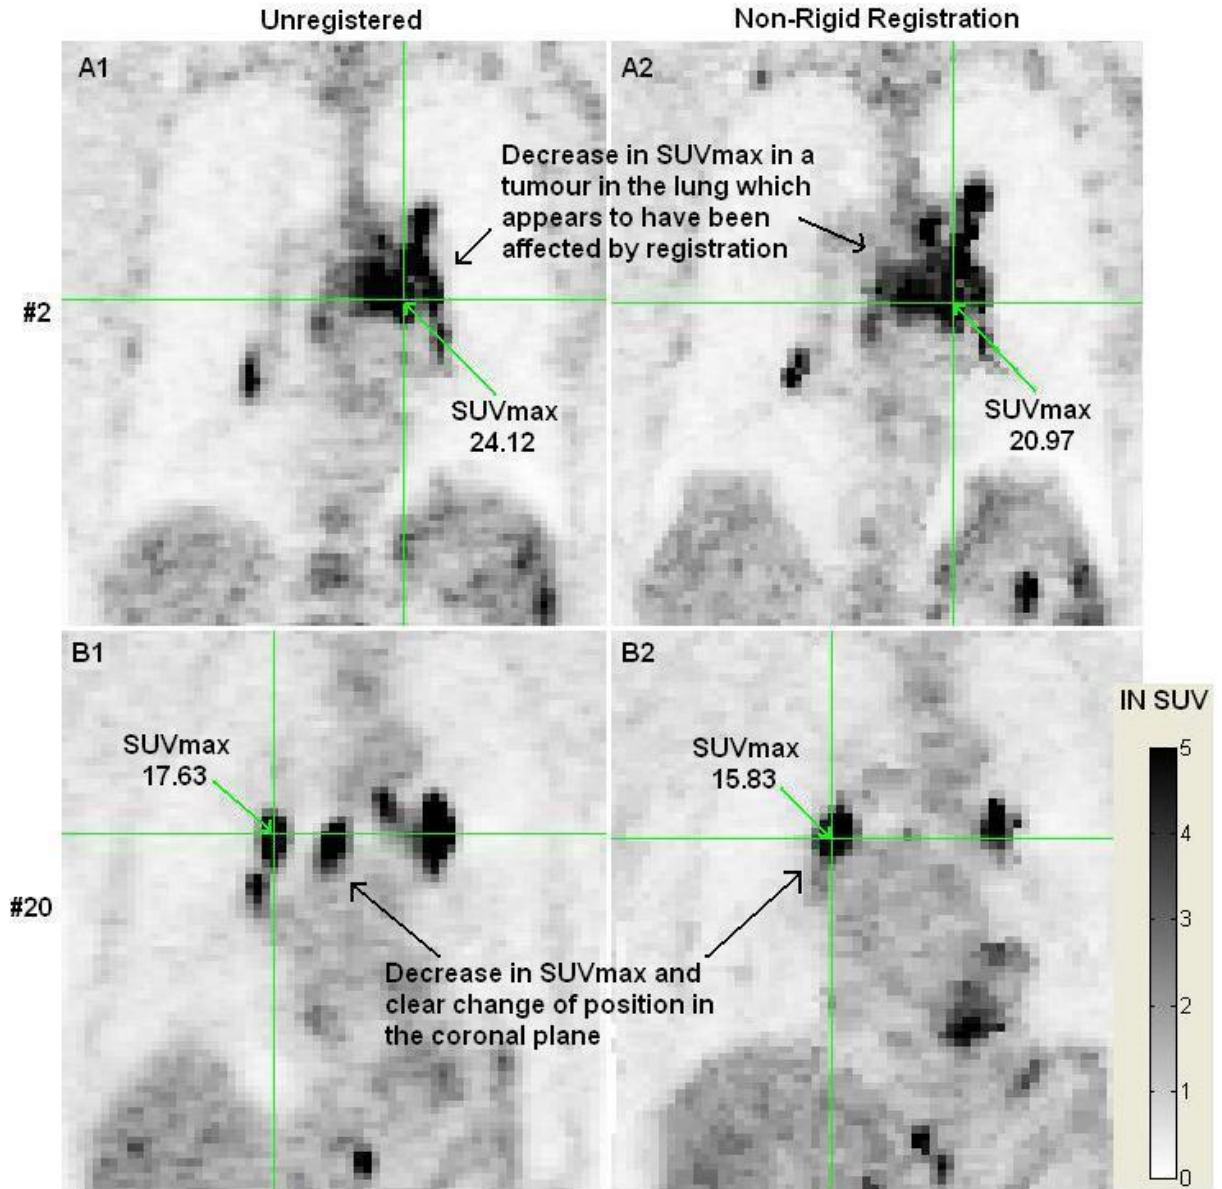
Changes in SUV_{max} between Unregistered and Registered Pre-Therapy Images
